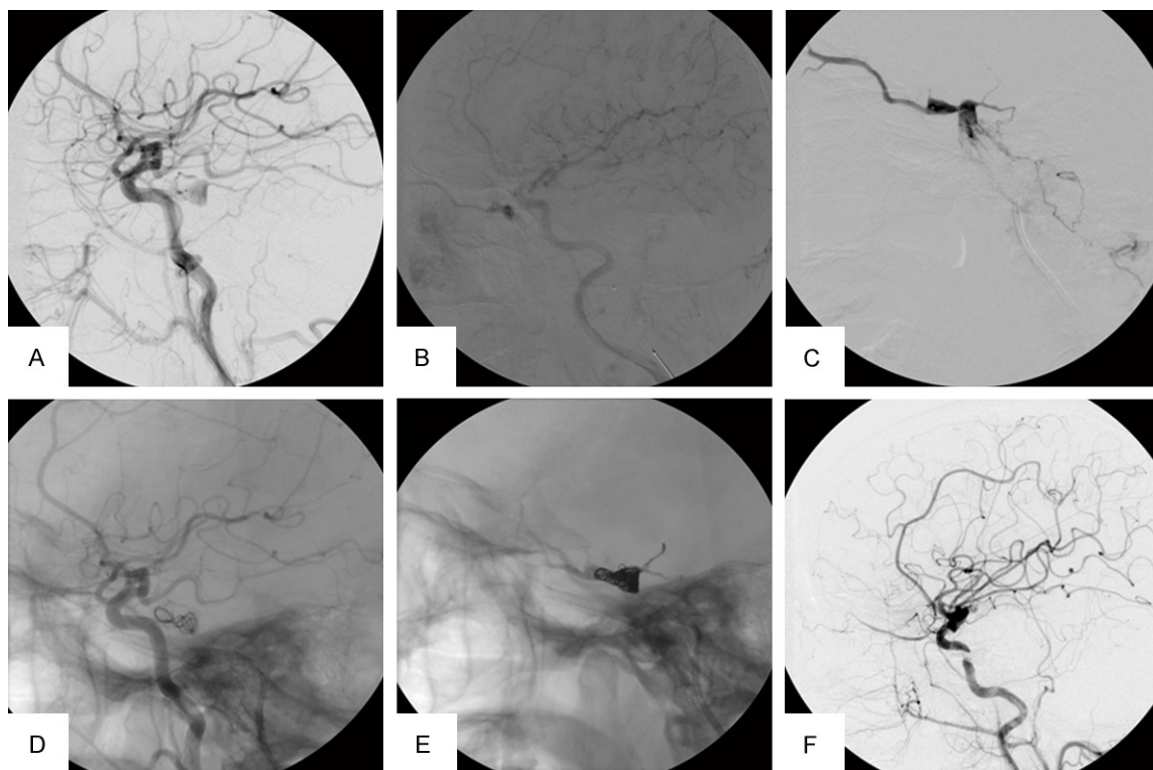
A and B. Pre-embolization, lateral projection: Left CCA injection arterial phase shows arteriovenous shunts in the right cavernous sinus (arrowhead) and right CCA angiography late arterial phase shows retrograde filling of the right SOV. C. Superselective angiography shows the cavernous sinus involved and drainage to the right SOV. D. Unsubtracted lateral view after deployment of detachable coils. E. Lateral skull radiograph shows the coils and Onyx mass in the right cavernous sinus. F. Post-embolization, Lateral projection: Right common carotid angiography shows no apparent arteriovenous shunts in cavernous sinus.
